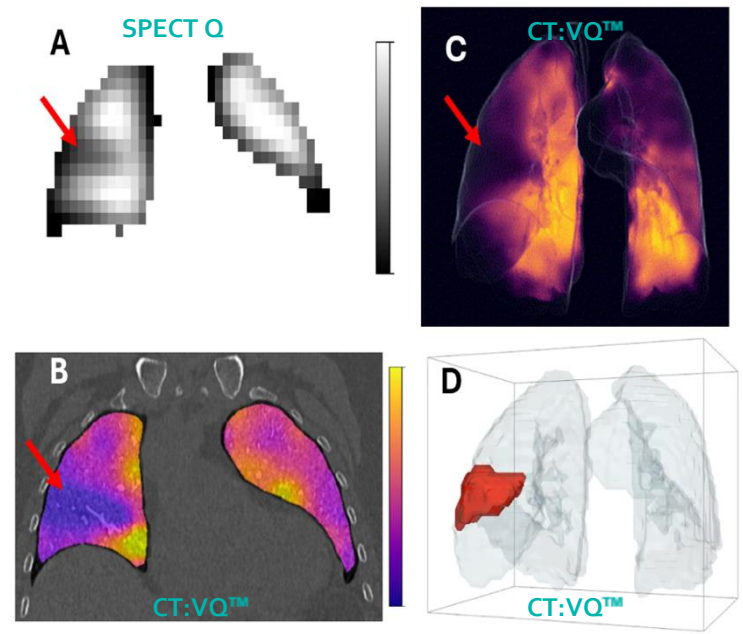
Example from a subject with a confirmed right middle lobe PE (red arrows point to the PE). A) Nuclear medicine SPECT coronal slice displaying the PE defect. B) CT:VQ coronal slice displaying the PE defect. C) 3D perfusion render from CT:VQ. D) PE model output for PE defect as 3D rendering (red).
